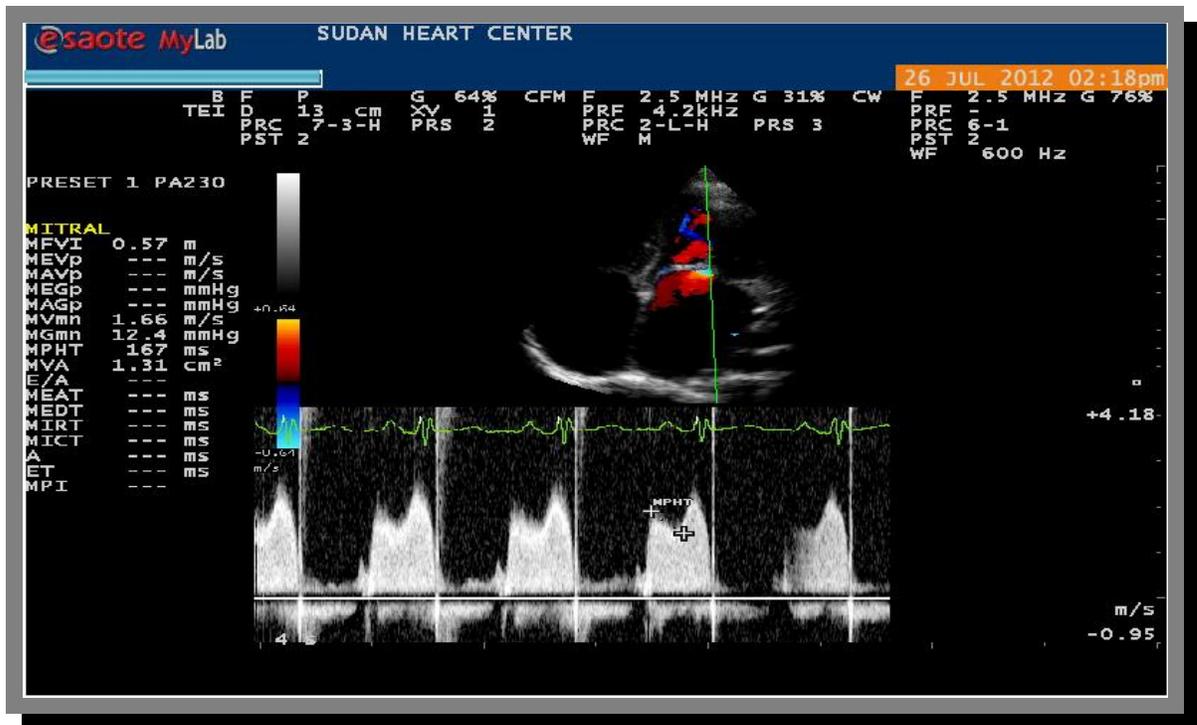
Continuous wave Doppler signal of mitral with a peak velocity of approximately 1.66 m/s.
